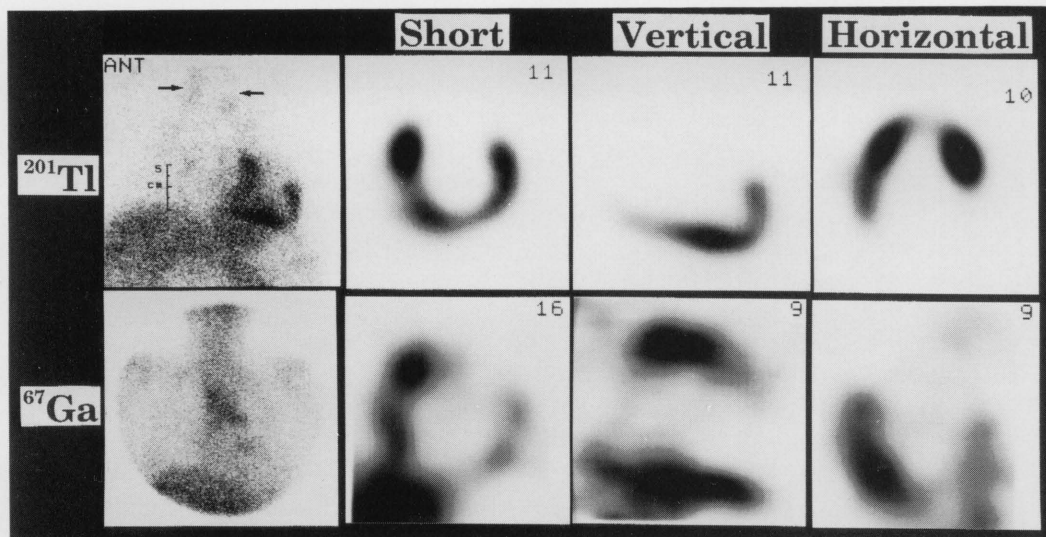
²⁰¹Tl and ⁶⁷Ga imaging before corticosteroid therapy. Abnormal ²⁰¹Tl uptake was observed in the regions of the bilateral lymph nodes (arrow), which was ascertained by positive ⁶⁷Ga accumulation in the same regions. Multiple focal defects of ²⁰¹Tl scintigram were found in the anterolateral and inferoposterior walls, where ⁶⁷Ga was accumulated.
